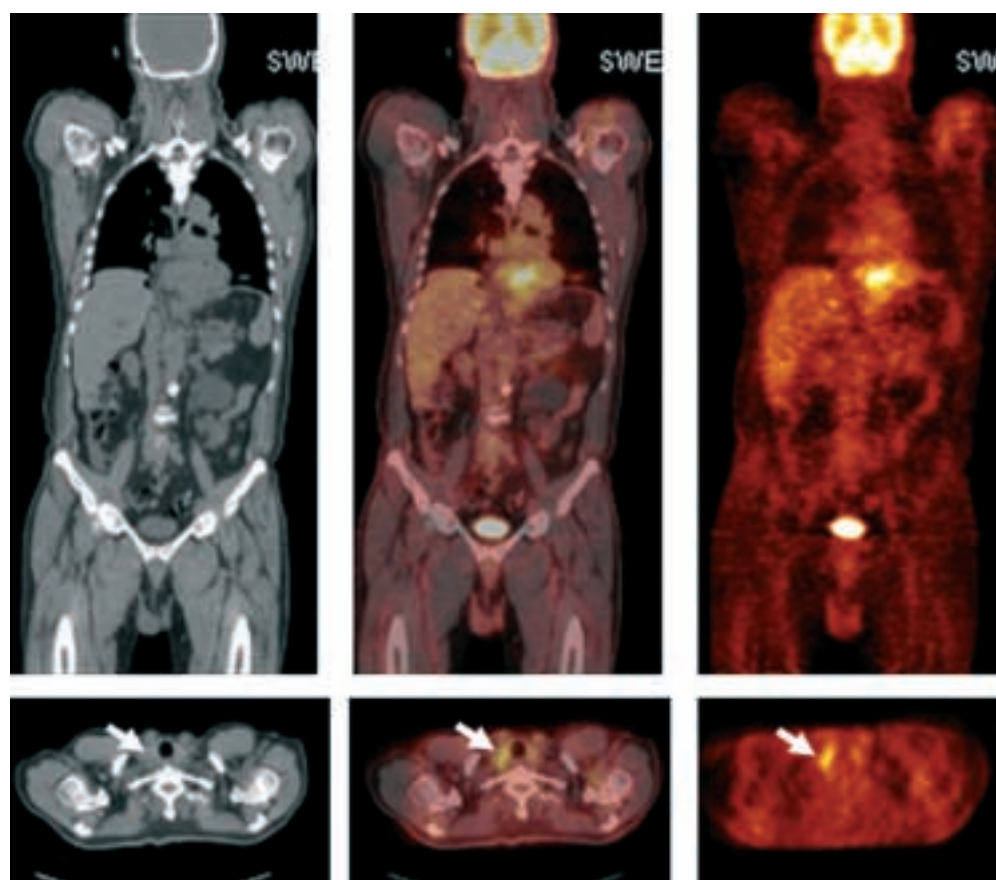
Staging esophageal cancer: 62-year-old man with adenocarcinoma of the distal esophagus and gastroesophageal junction. Coronal (*top*) CT, PET/CT fusion, and PET images demonstrate intense FDG uptake within the primary tumor mass. Transaxial (*bottom*) CT, PET/CT fusion, and PET images show intense FDG uptake in a normal size (1 cm) right supraclavicular lymph node (*arrows*), which was easily accessible for biopsy to confirm inoperable disease.
